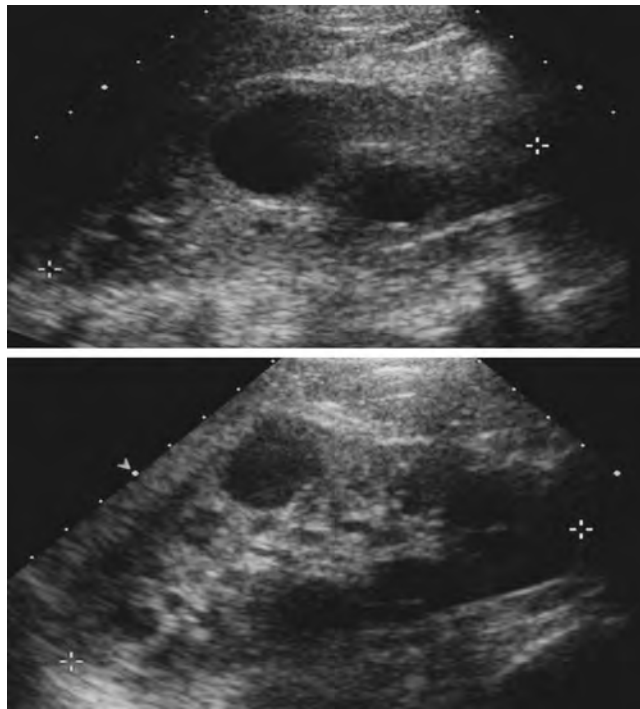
Renal ultrasonogram of 20-year-old patient newly diagnosed with autosomal dominant polycystic kidney disease. Note the presence of multiple cysts in both kidneys. (Courtesy Marta Hernanz-Schulman, MD.)
